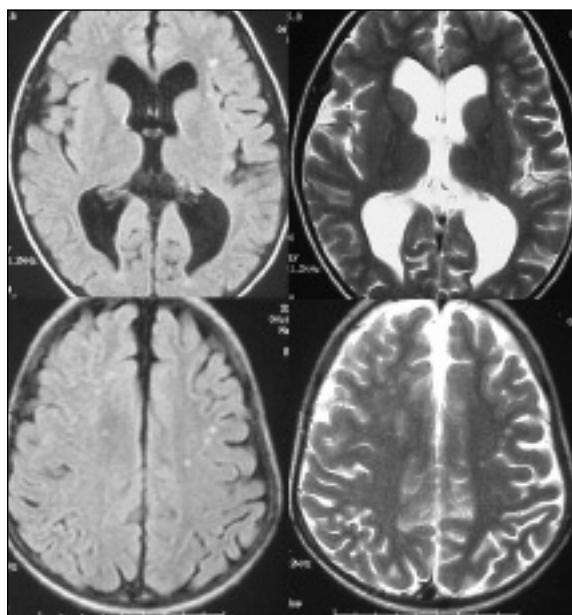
Magnetic resonance imaging (MRI) of the brain revealed on FLAIR and T2-weighted axial resonance imaging, lesion at the subcortical white matter and semioval center suggesting gliosis, associated to cortical/subcortical atrophy with non-hypertensive dilation of the lateral brain ventricles.
